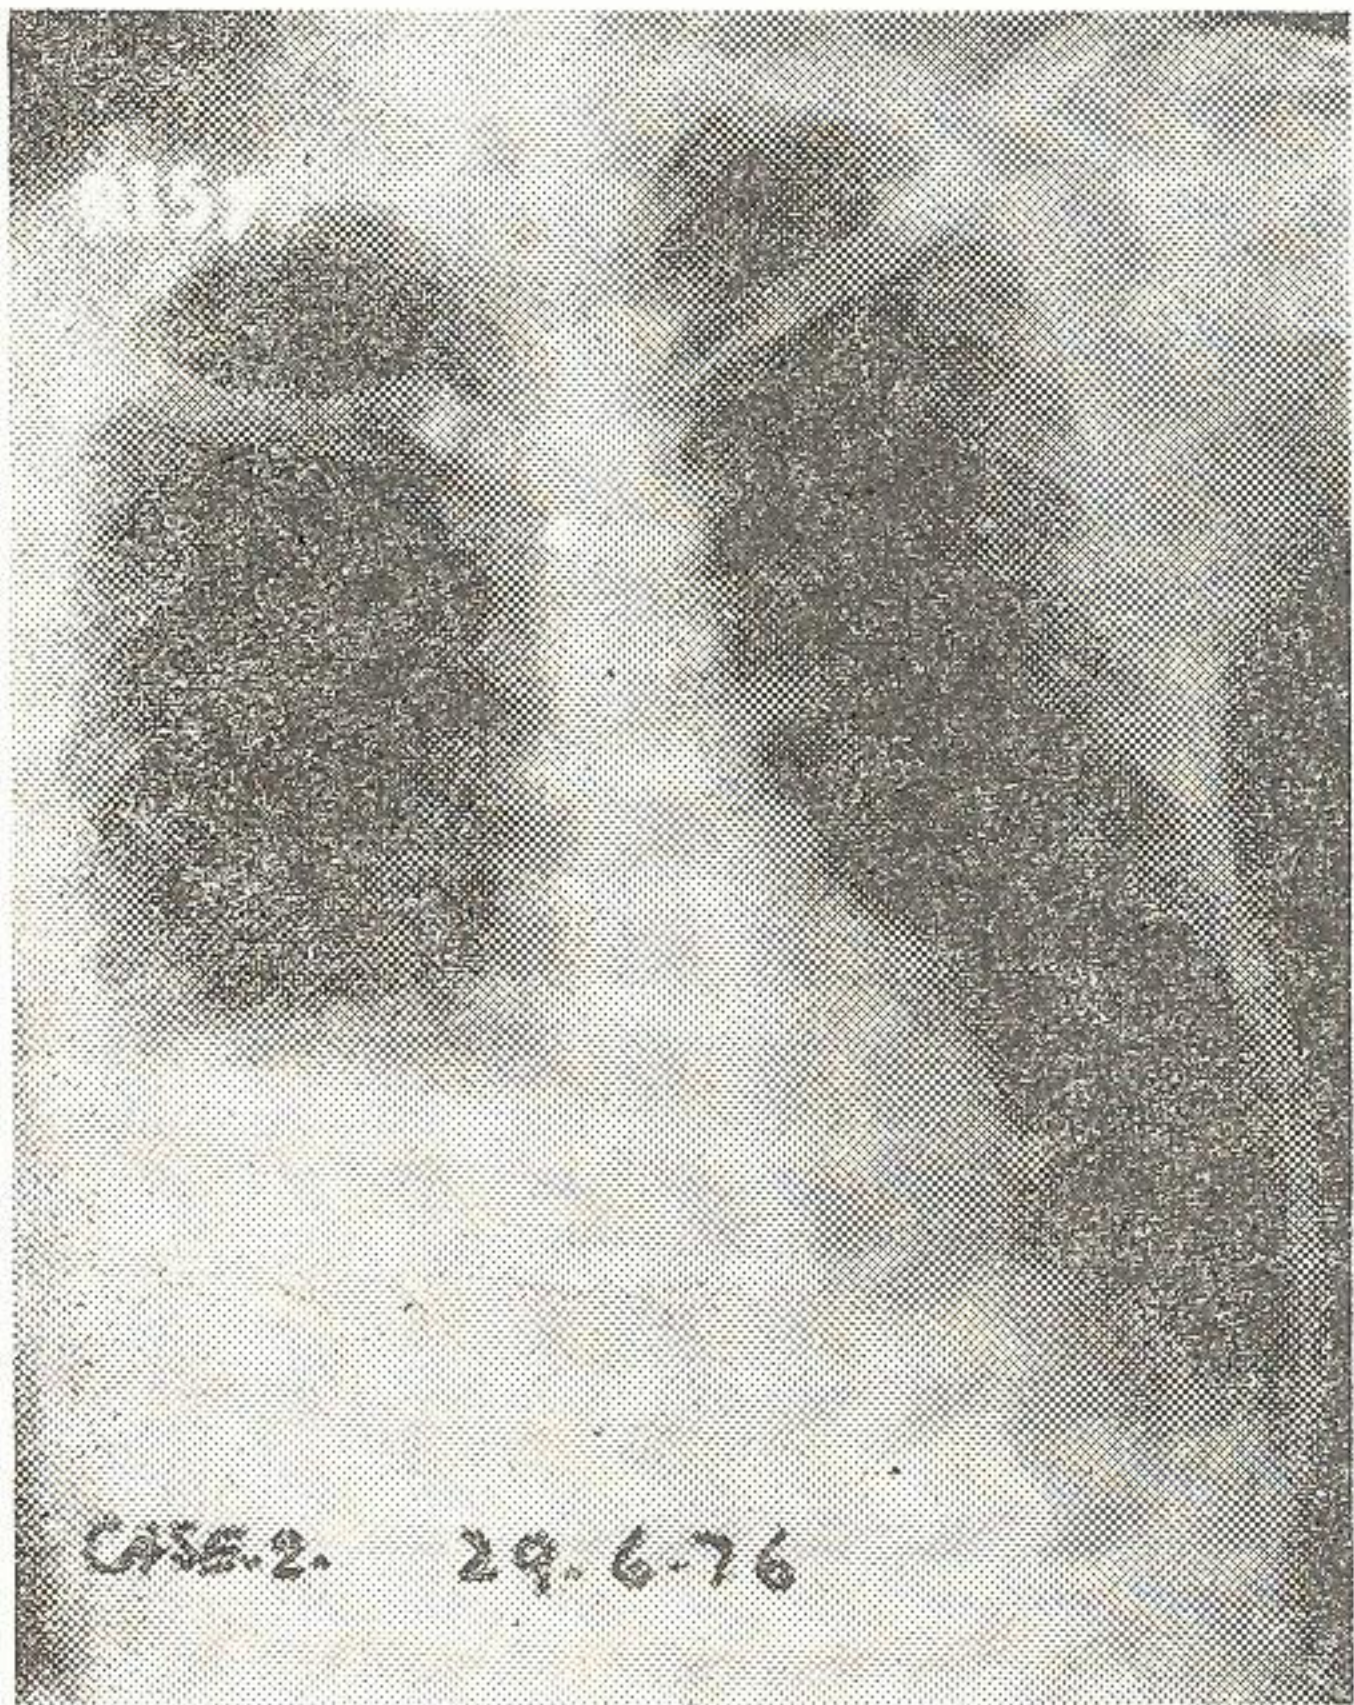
Case-2 (29-6-1976). X-Ray chest P.A. view showing pleural effusion at the right base of the lung.
